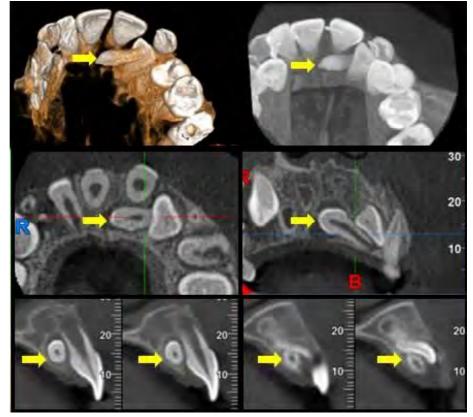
Axial and sagittal views of CBCT
